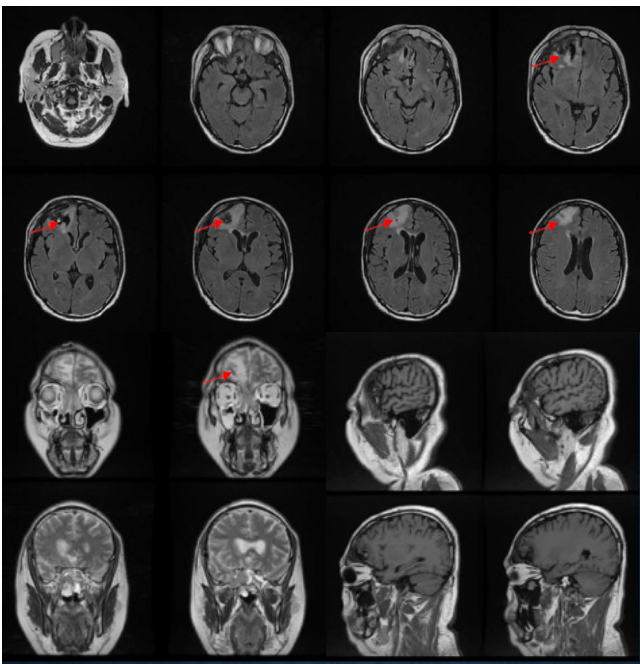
Postoperative axial, coronal, and sagittal brain MRI sequence with contrast on December 22nd, 2022
